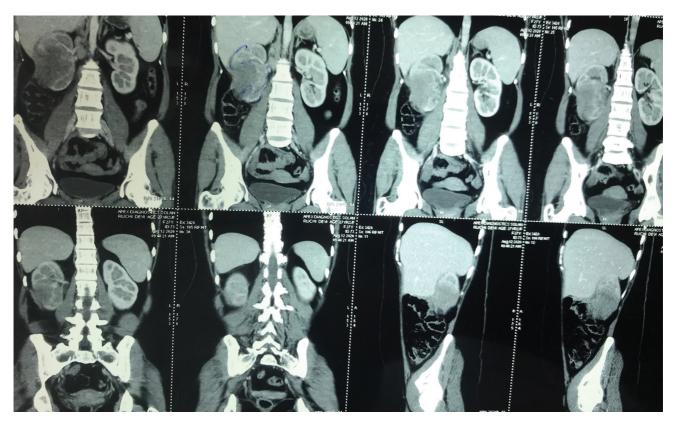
Coronal sections of the contrast-enhanced computed tomography abdomen show heterogenous mass mid and lower pole with ill-defined margins, perinephric stranding, and involving duodenum.
